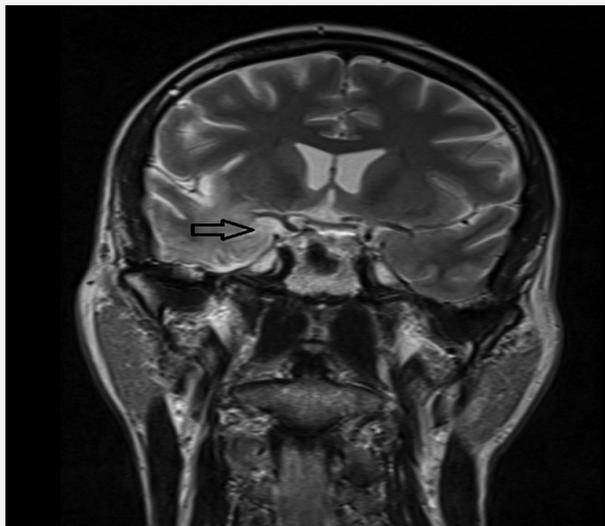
T2 weighted MRI showing hyperintensity in right temporal lobe
